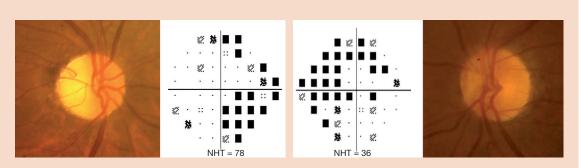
Predominantly nasal perimetric defect in both eyes, although it crosses the vertical raphe in the right eye, associated with a pallor of the temporal disc in the right eye. The indices of the Neurological Hemifield Test (NHT) of both eyes suggest damage of neurological origin. The nuclear magnetic resonance imaging test revealed a compression of the optic nerve due to an elongation of the right supraclinoid segment of the artery, which was treated with neurosurgery.
